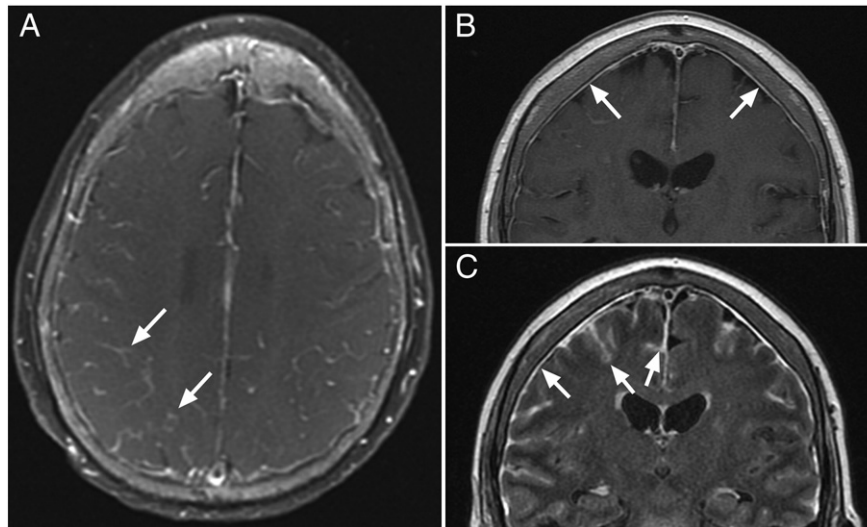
Axial spin echo T1-weighted with fat saturation (repetition time [TR] 650/echo time [TE] 20) (A), coronal spin echo T1-weighted (TR416/TE13) (B), and T2W-FLAIR (TR11002/TE149) (C) postgadolinium images from the initial brain MRI demonstrate profound diffuse leptomeningeal (A, C) and mild pachymeningeal (B, C) enhancement (examples at arrows).
